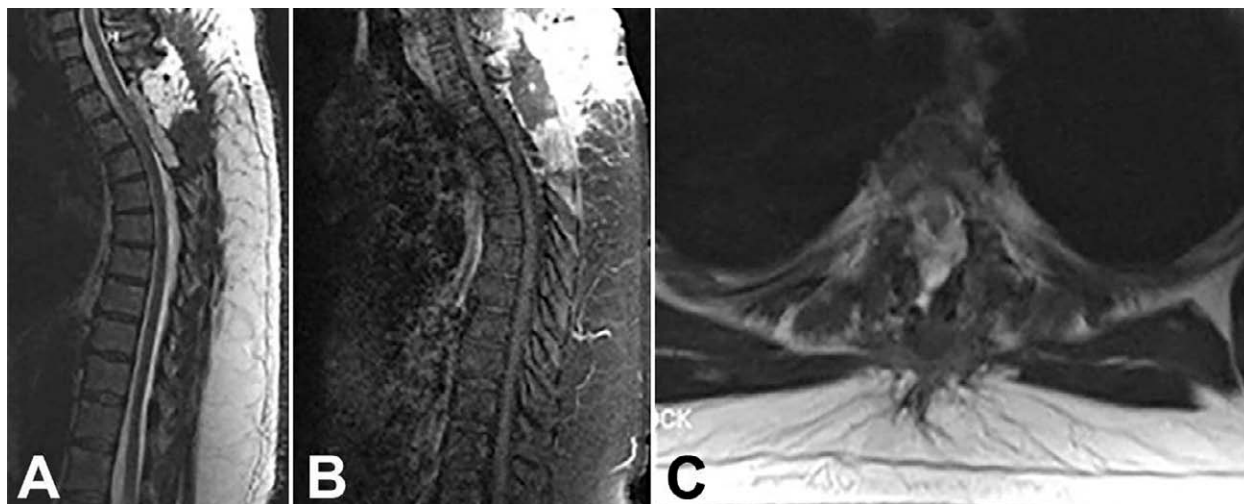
Postoperative sagittal (A), post-contrast sagittal (B), and axial (C) magnetic resonance imaging of the thoracic spine showing successful gross total tumor microsurgical resection.
